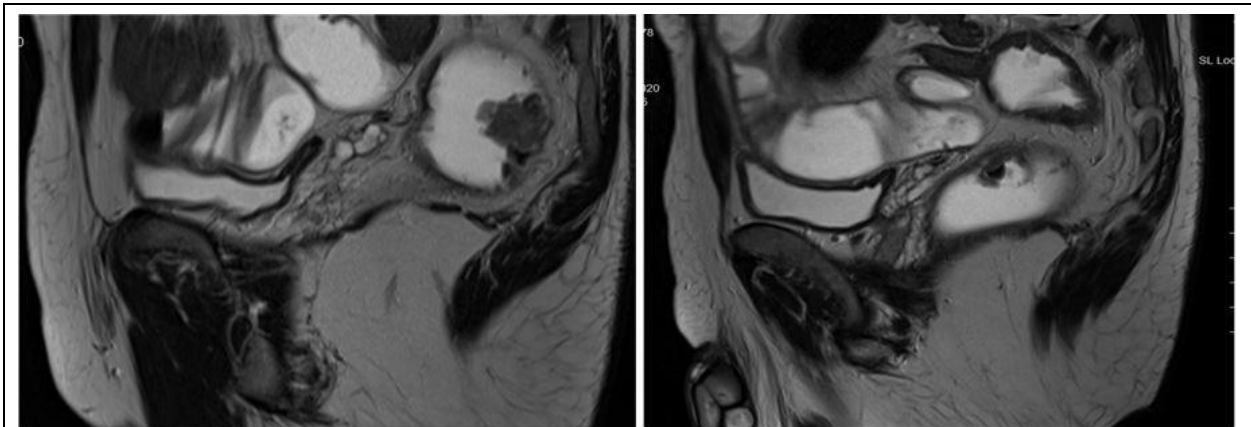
MRI picture after chemotherapy treatment.
